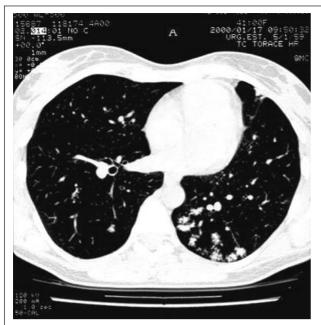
High resolution computed tomography (HRCT) scan of patient 1 at the beginning of treatment with LFX, showing a "tree-in-bud" appearance.
